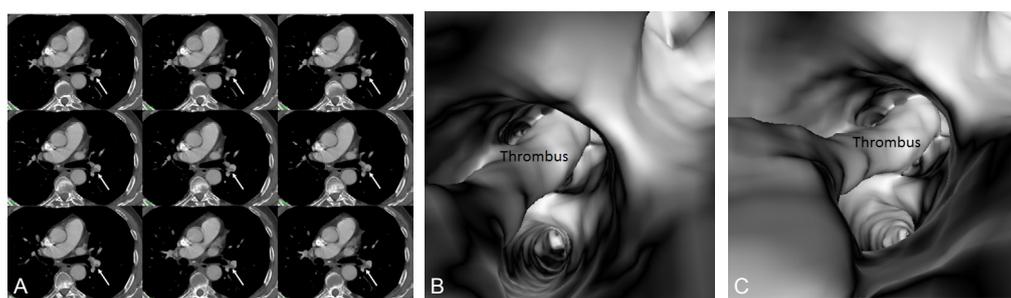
CT Pulmonary Angiography Shows Pulmonary Embolism in a 65-Year-Old Man. A: 2D Axial Images Demonstrate Thrombus in the Left Lower Lobar Artery (arrows). B and C: 3D Virtual Intravascular Endoscopy Offers Intraluminal Views of the Thrombus in the Left Lower Lobar Artery in Relation to the Surrounding Branch Artery.
